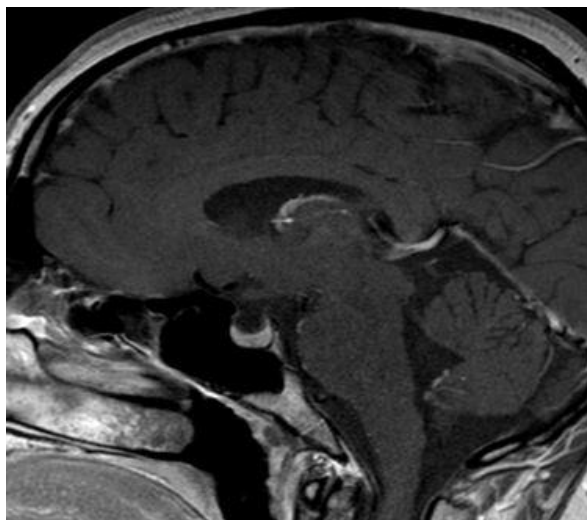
MRI Brain showing Partial Empty Sella of Case 3.
